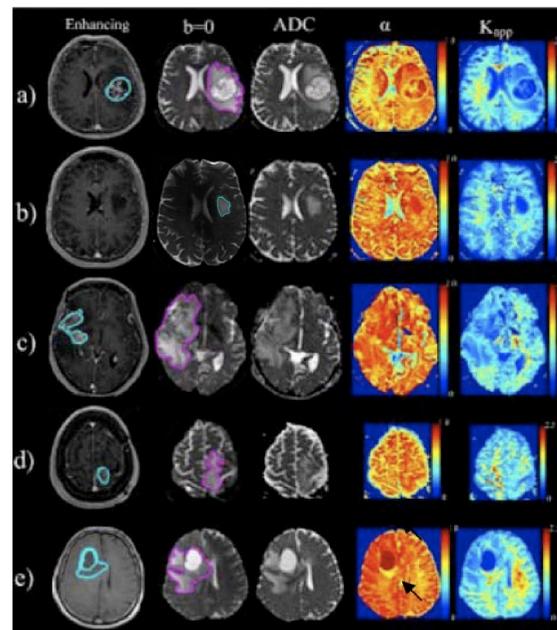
Columns from left to right: T1-weighted contrast-enhanced MR, T2-weighted MR, ADC maps, α -heterogeneity maps (orange), and DKI maps (blue) for patients (a – e).
